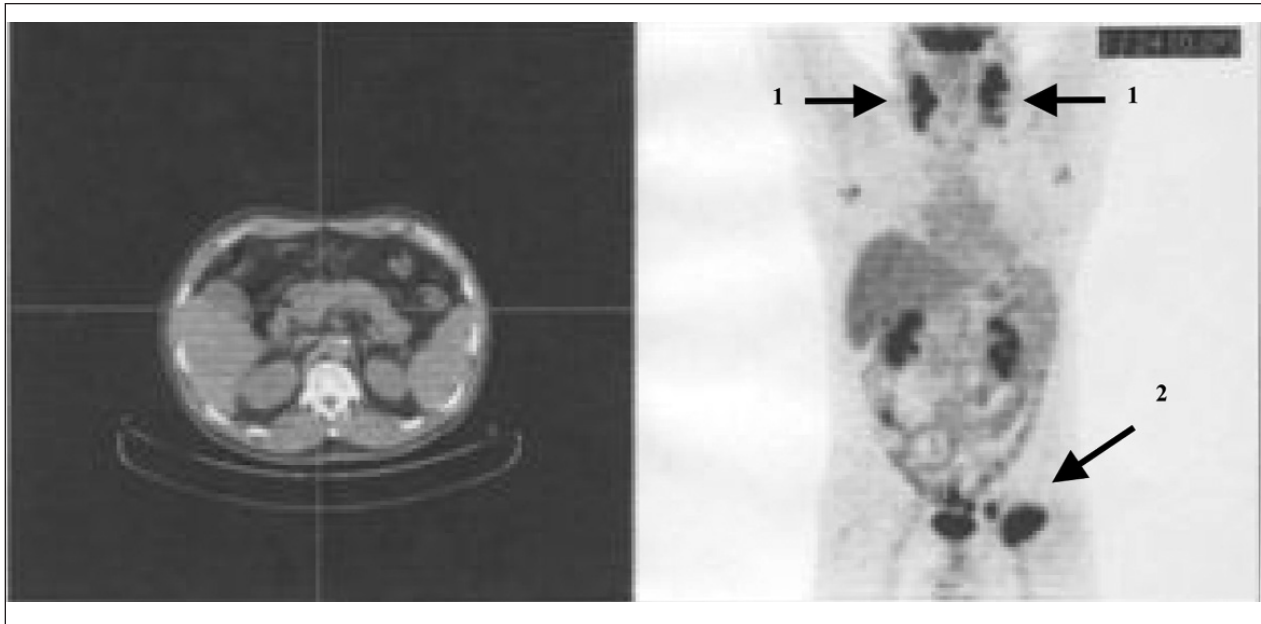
Computed tomography/positron emission tomography scans of December 13, 2005, demonstrate large bilateral cervical lymphadenopathy (arrows 1) and large left-sided inguinal node (arrow 2).
